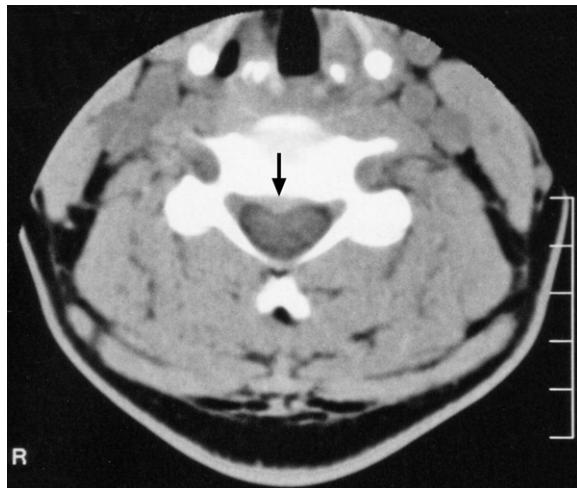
Cervical spine CT axial image. Note that the report stated: 'There is a small focal disc protrusion at the C4/5 level posteriorly in the midline causing minor indentation on the cervical spinal cord'.
